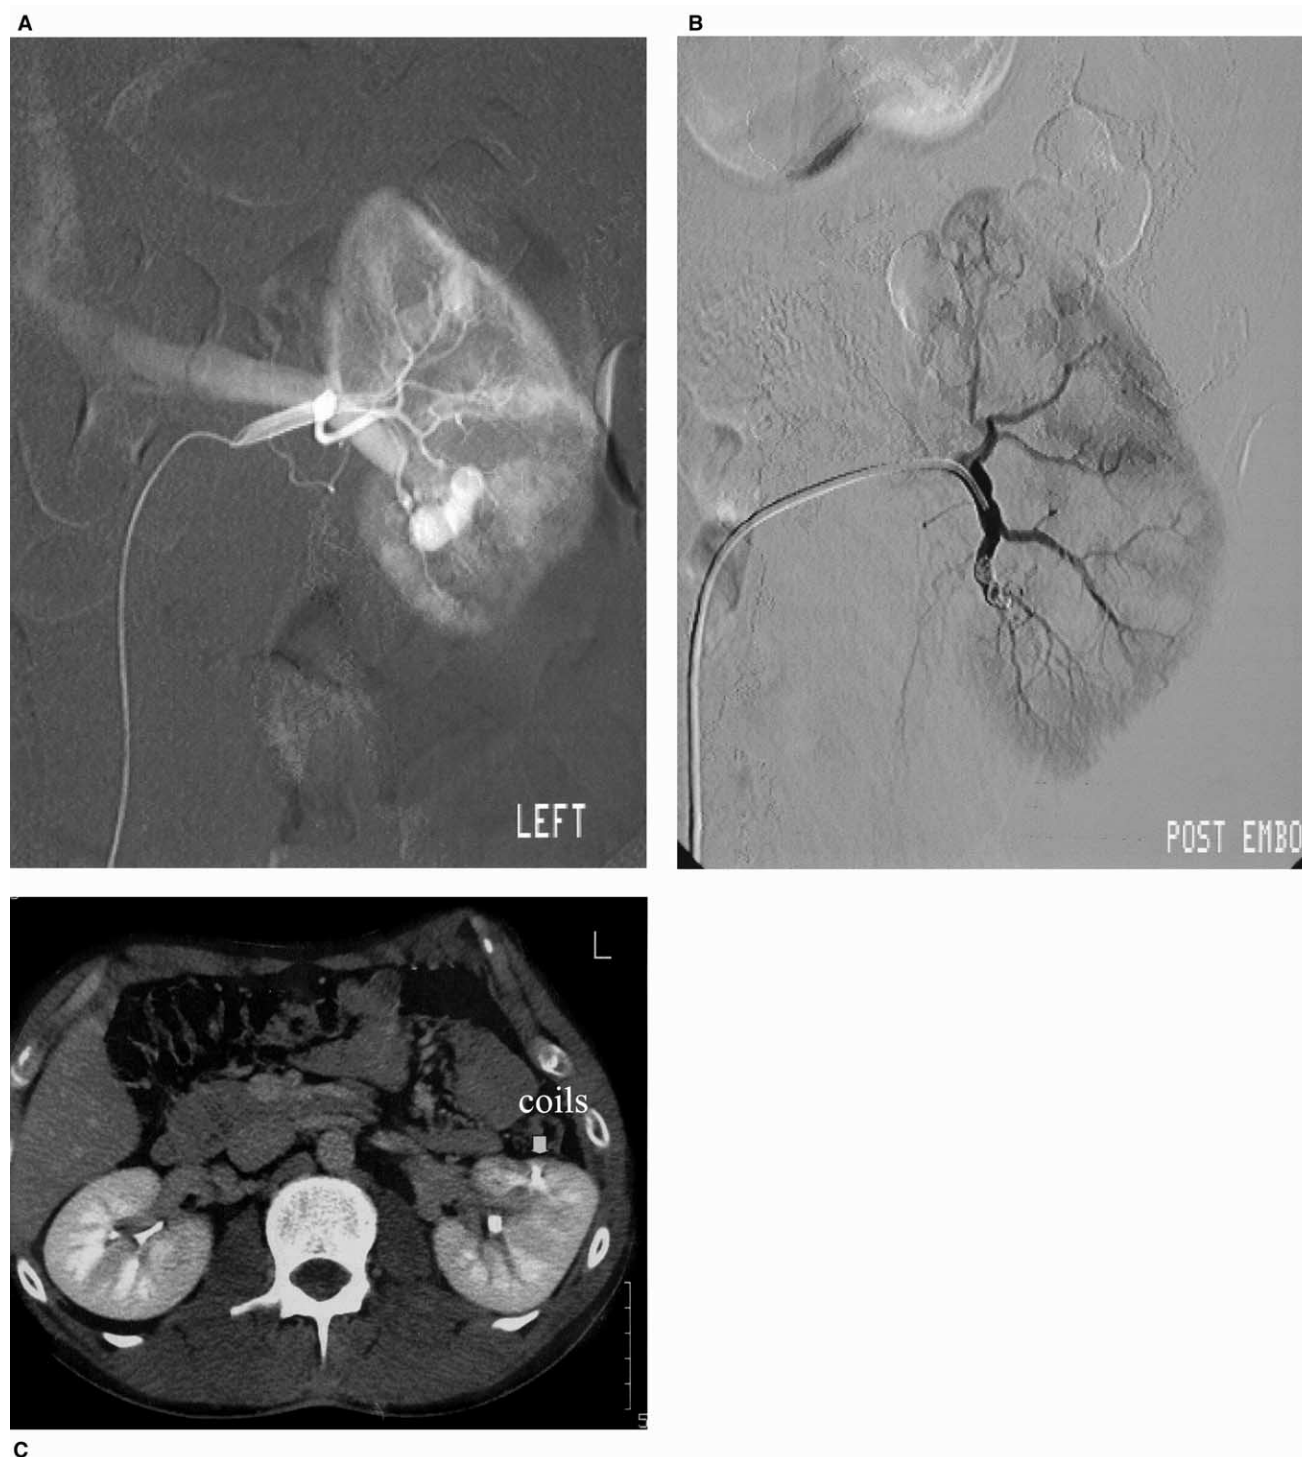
(A) Selective renal DSA depicting a bilobar pseudoaneurysm with simultaneous arteriovenous fistula. (B) DSA after superselective embolization with 0.035-inch coils shows total occlusion of the injury site with minimal non-perfused area of the renal parenchyma. (C) Contrast enhanced CT 8 months after the embolization shows no significant residual parenchymal infarction. The hyperdense area within the parenchyma represents the coils (arrow).
